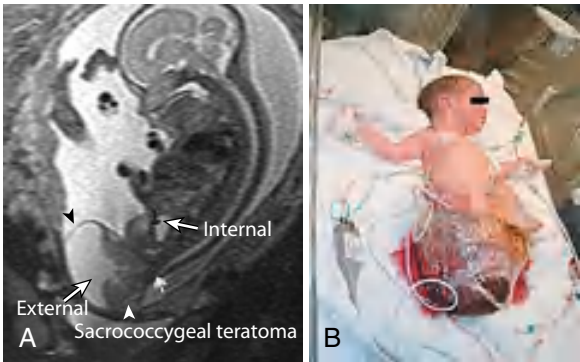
A, Prenatal MR image showing sacrococcygeal teratoma with a small internal and large external component. B, Postnatal large, bleeding sacrococcygeal teratoma. (From Lakhoo K. Neonatal teratomas. *Early Hum Dev*. 2010;86:643–647.)
